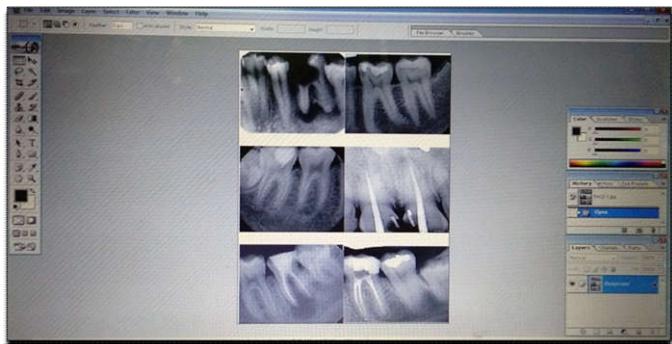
Teledentistry approach for diagnosis of periapical lesions
